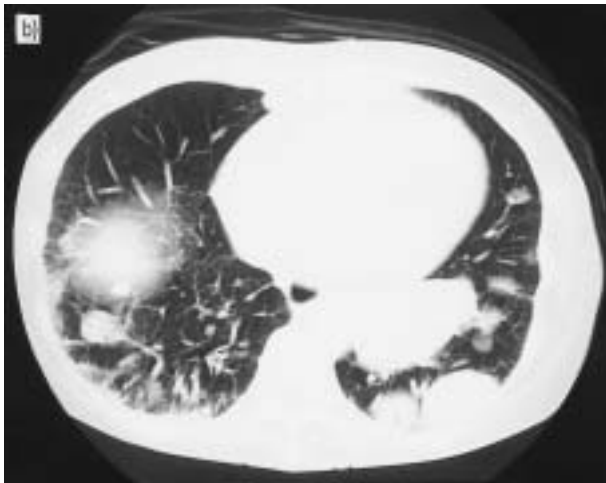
a) Chest radiograph revealing multiple tumour lesions with bilateral basal fibrotic changes. b) Chest computed tomography scan showing a 3.4×6.6 cm primary tumour lesion located in the left S<sup>9</sup> area. Multiple metastatic lesions were also demonstrated.
